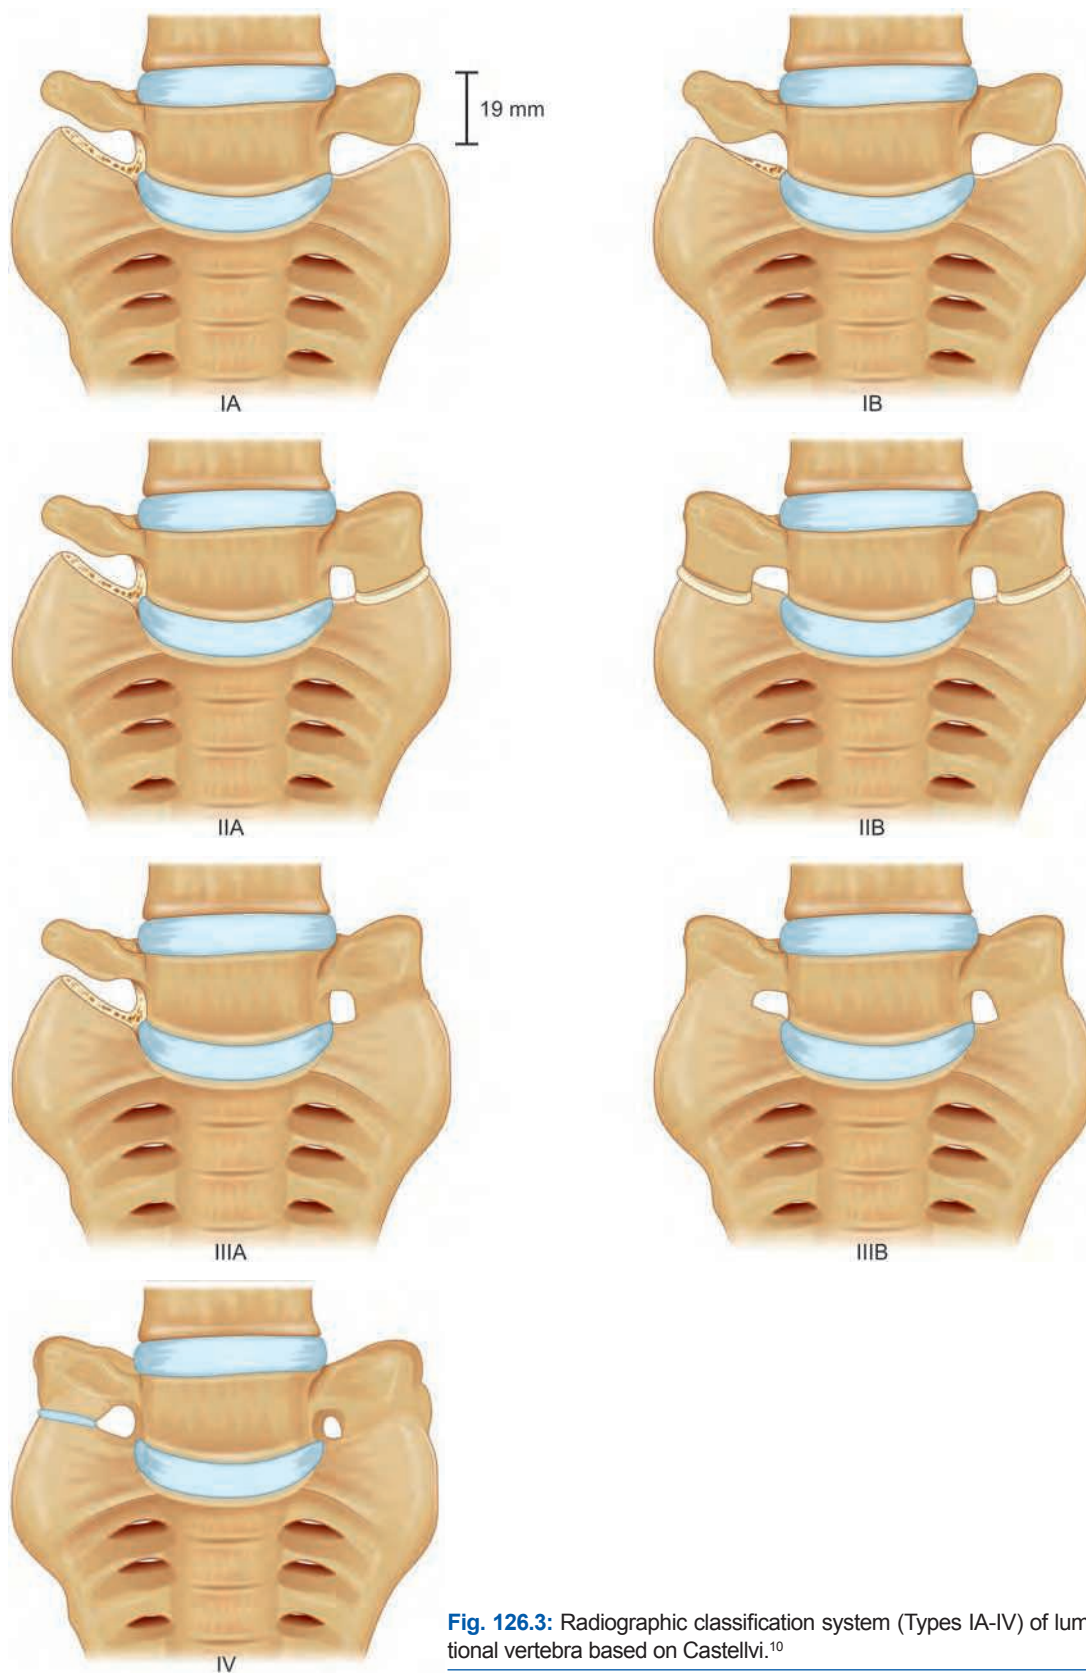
Radiographic classification system (Types IA-IV) of lumbosacral transitional vertebra based on Castellvi.¹⁰
